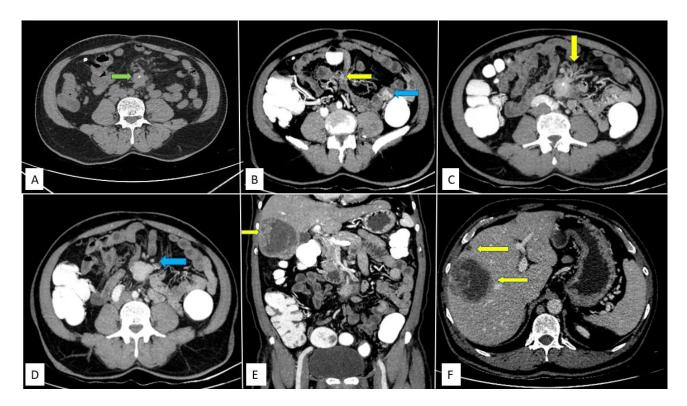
A 67-year-old male presented with abdominal pain. CECT Abdomen was done. A) Axial CT show an irregularly marginated heterogeneously enhancing lesion involving the mesentery in the supraumbilical location just anterior to the aortic bifurcation with a tiny calcific focus (green arrow). B) Axial CT show tethering of multiple adjacent small bowel loops (yellow arrow). The small heterogeneously enhancing lesion in the adjacent Ileal loop (blue arrow). C) Axial CT show adjacent neo-angiogenesis and fat stranding (Yellow arrow) D) Axial CT show multiple sub-centimetric enhancing mesenteric lymph nodes (blue). E& F) Coronal and axial CT show multiple well-defined heterogeneously enhancing hypodense lesions in theliver (yellow arrows).
